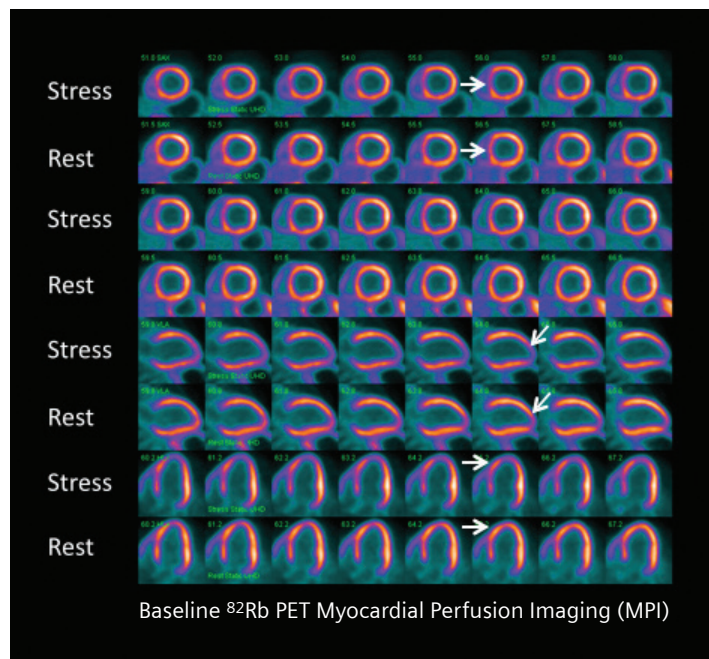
Summed stress and rest images of the baseline  $^{82}\text{Rb}$  PET/CT myocardial perfusion study show a dilated LV and a reversible perfusion defect in the septum and apex.
